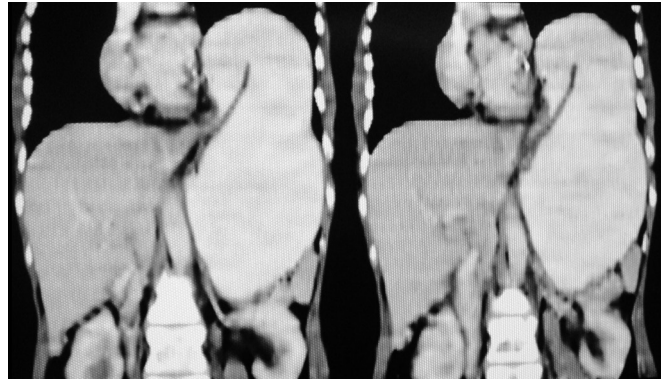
Contrast-enhanced coronal CT image shows mesenteroaxial volvulus.
